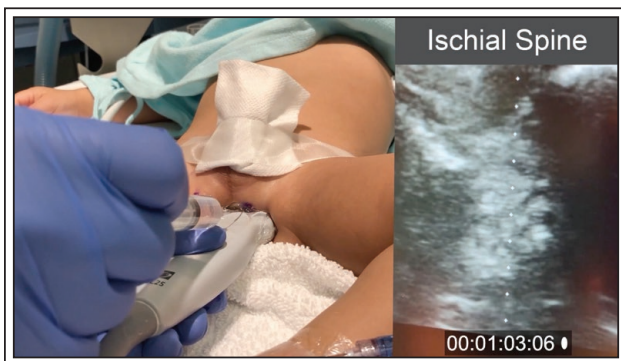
Ultrasound guided pudendal nerve block technique. Prior to injection of local anesthetic, there is adequate visualization of the ischial spine (hyperechoic semicircle with an inferior hypoechoic bone shadow).
